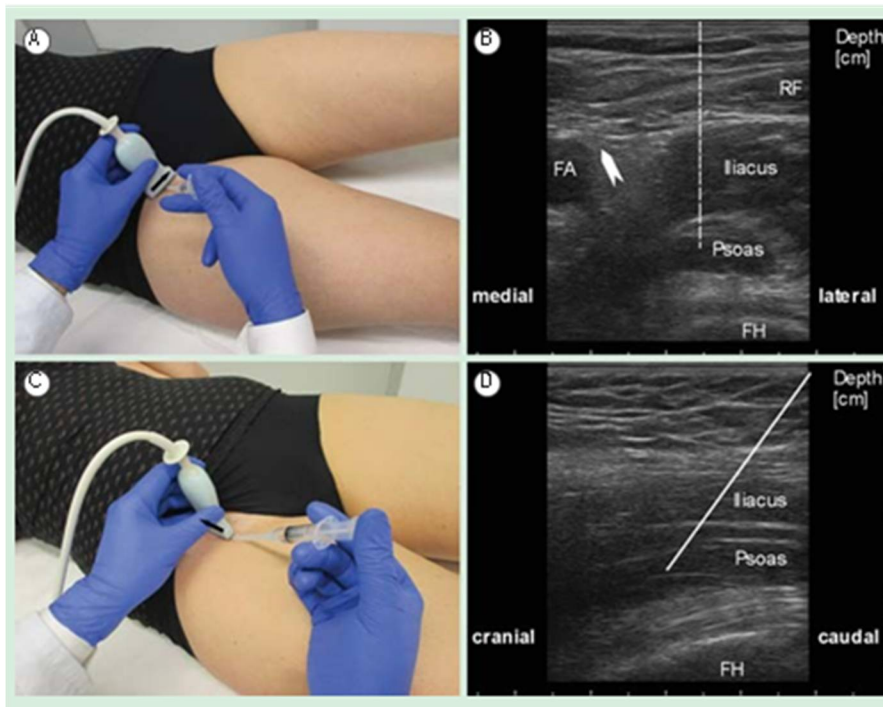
US of the inguinal region for guiding BT injection into the psoas muscle. (A) Position of ultrasound transducer and syringe (off-plane injection technique). The arrow indicates the orientation of the transducer (arrowhead corresponding to the left side of US image shown in (B)). (B) US image showing the psoas, iliacus and RF muscles and neighboring structures. The arrowhead indicates the femoral nerve. The dashed line indicates the expected path of injection needle. (C) Position of ultrasound transducer and syringe (in-plane injection technique). The arrow indicates the orientation of the transducer (arrowhead corresponding to the left side of US image shown in (D)).
